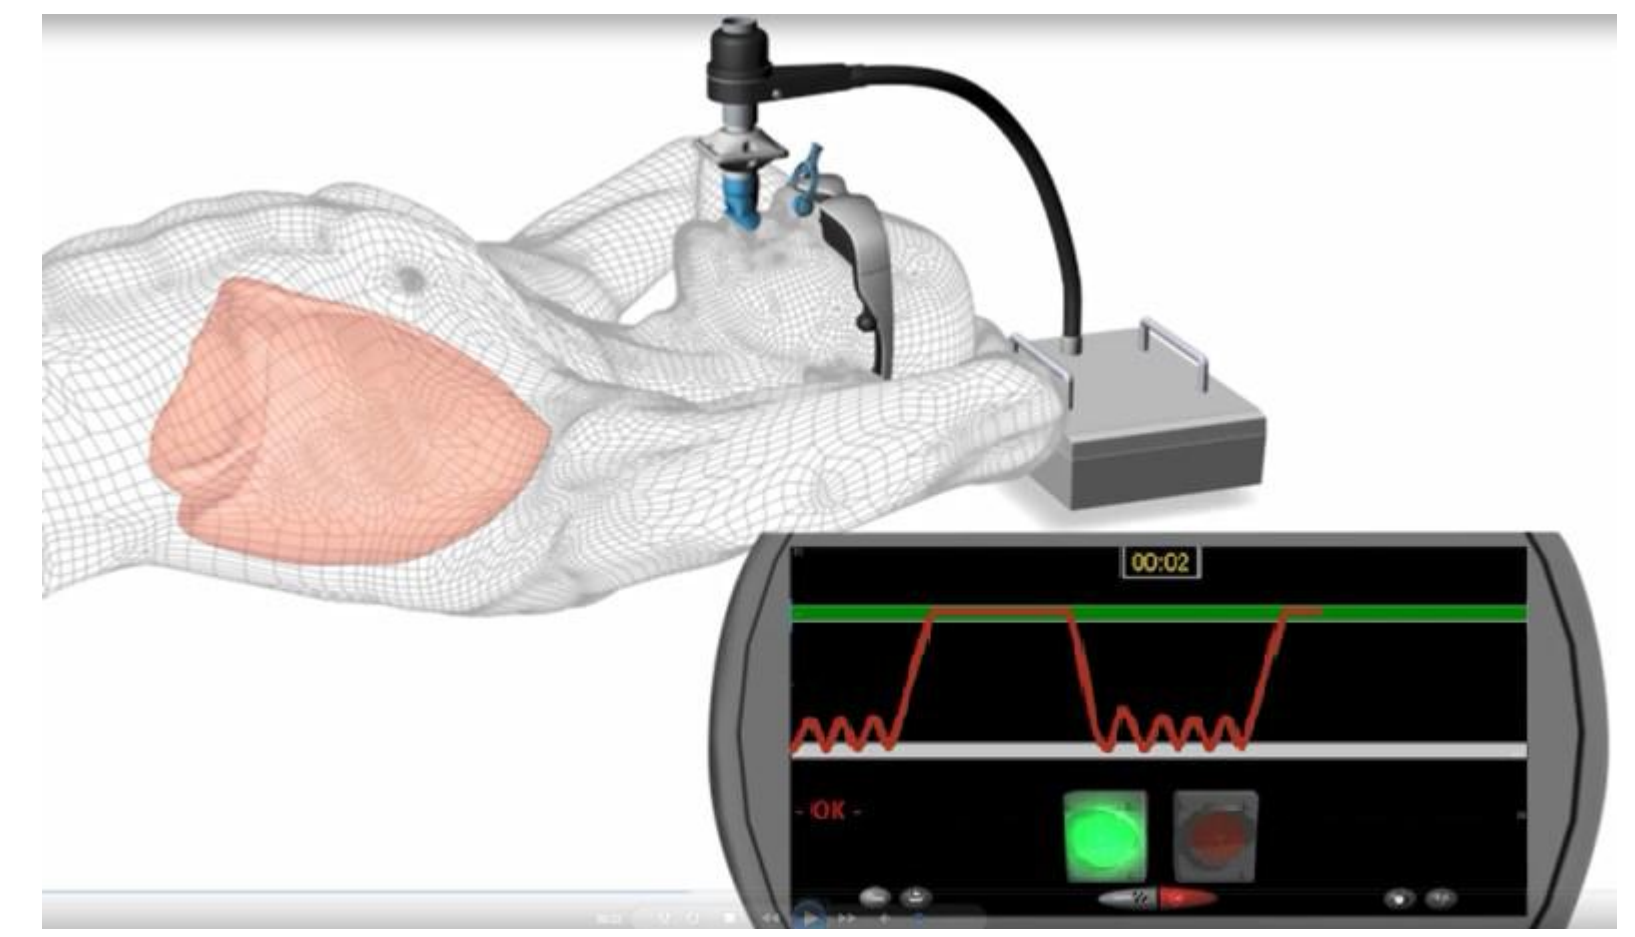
X-ray imaging setup conditions
